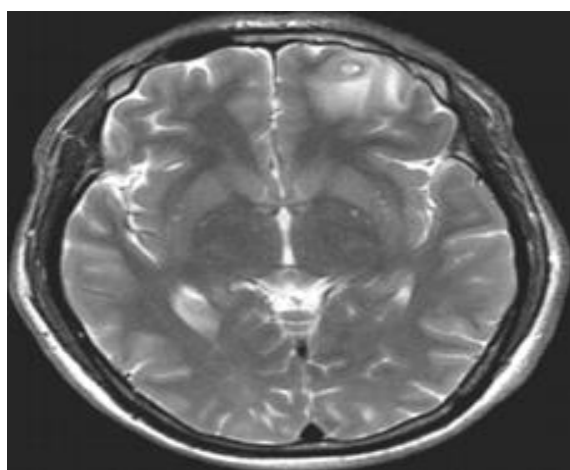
MRI showing Neurocysticercosis in left frontal lobe
